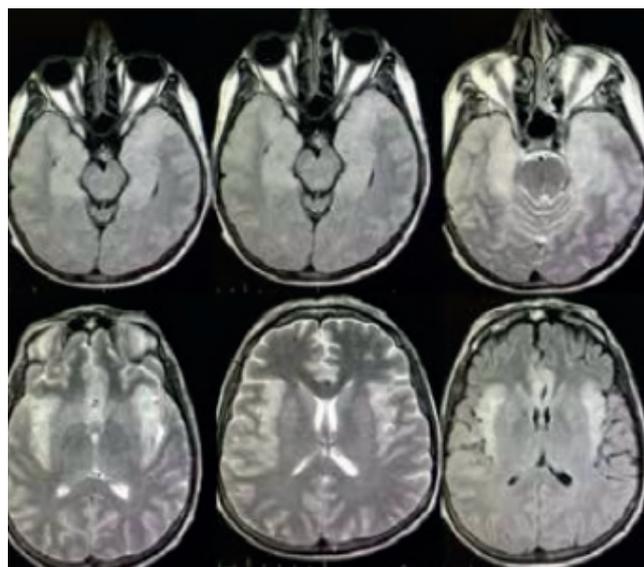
MRI scan of the patient shows bilaterally inflammatory T2 signals in the hippocampus, temporal lobe, and insula.
